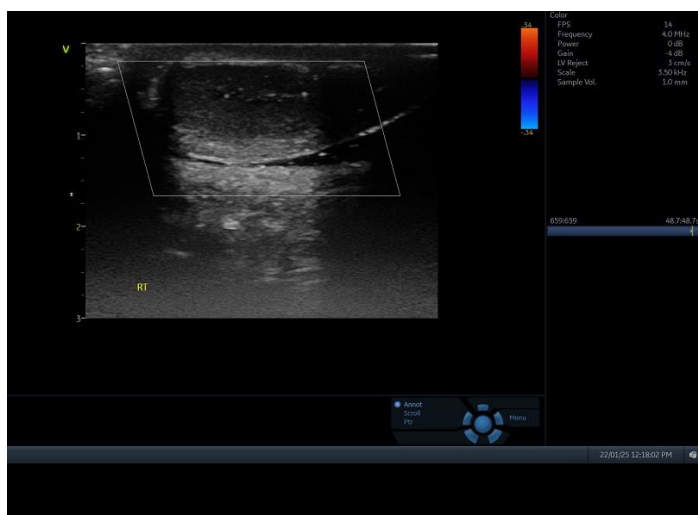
Longitudinal ultrasound scan showing testicular microlithiasis (classic) with multiple punctate calcifications in the right testicular parenchyma.
